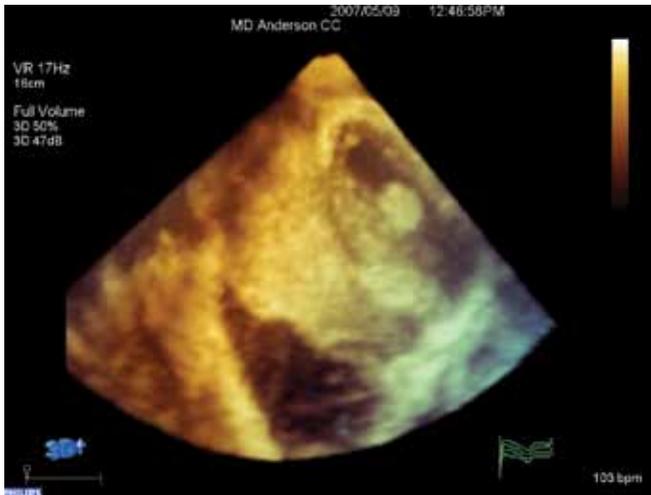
Full-volume acquisition obtained from the parasternal long axis view of a 35-year-old female with a primary cardiac sarcoma. There is evidence of a large exophytic mass originating from the base and mid segments of the inferolateral wall. An intracavitary mass is also visualized, originating from the mid segment of the inferior wall.
